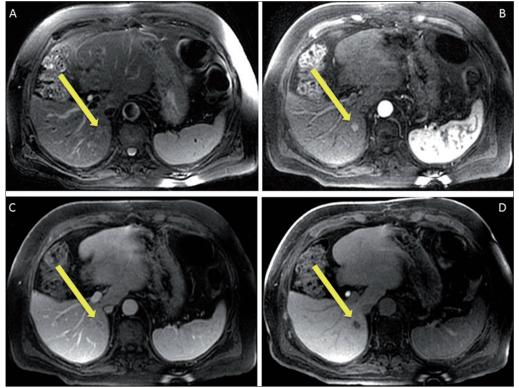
Well-differentiated HCC. A, On T2-weighted fat suppressed axial image a small nod-ule barely hyperintense is shown. B, At dynamic imaging, in the arterial phase, the nodule is hypervascular. *C*, The nodule is slightly hypointense in the venous phase. D, In delayed phase imaging the nodule is definitely hypointense relative to surrounding liver parenchyma
